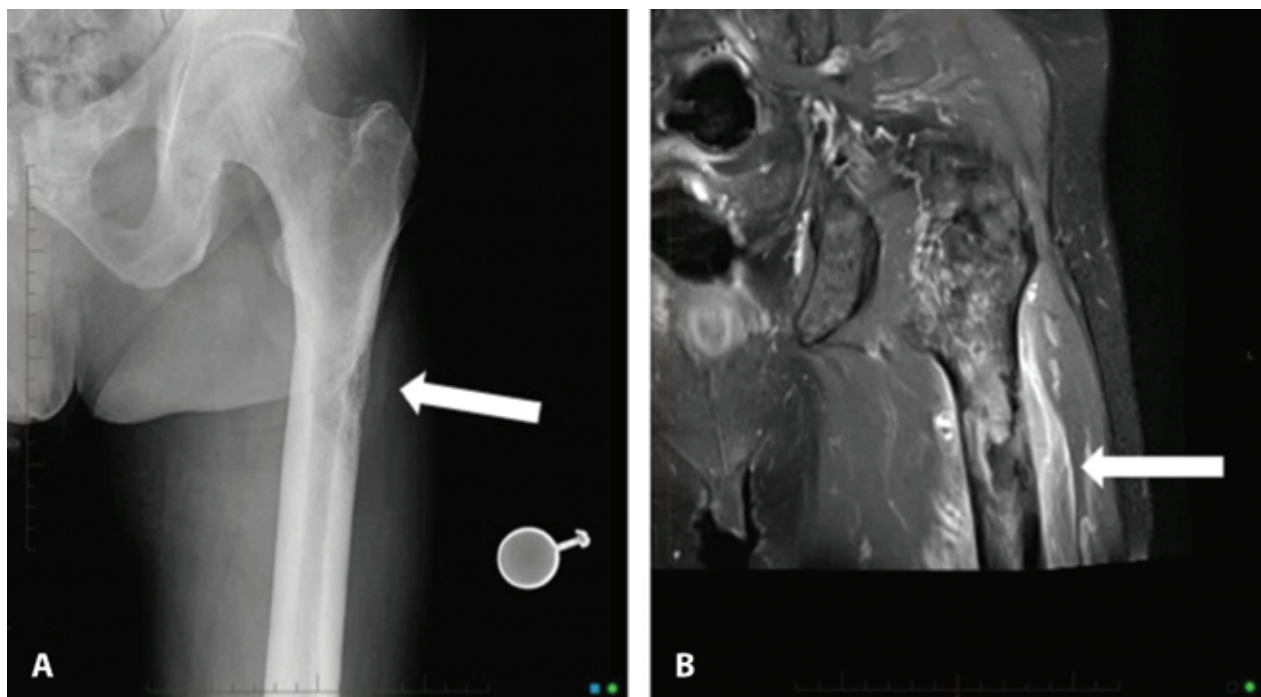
Left femur imaging. A plain radiograph of the left proximal femur identifies a sub-trochanteric permeative, lytic bone lesion with cortical destruction (A), which is also documented after T2-weighted fat-saturated MRI of the left proximal femur with notable intramedullary fibrosis, marked heterogeneity of the marrow, and associated soft tissue edema surrounding the proximal femur (B) (From ref. 47; Reproduced with permission of Editor).
